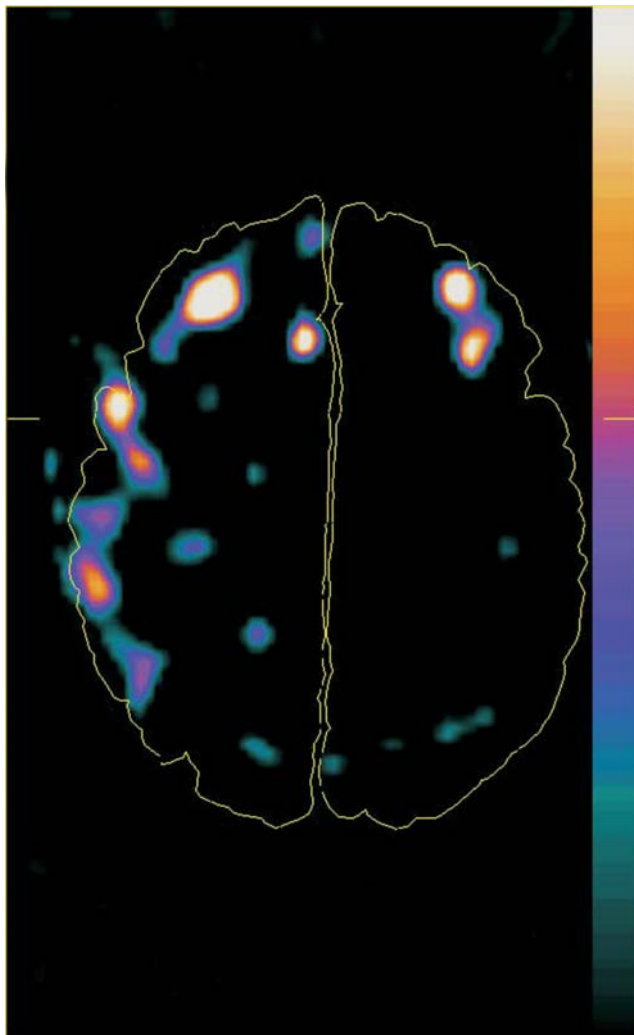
Image highlighting the regions in which A CBF distribution is higher than NA CBF distribution. The image is obtained by subtracting the average SPECT CBF data pool of NA ($n = 33$), from A ($n = 14$)
